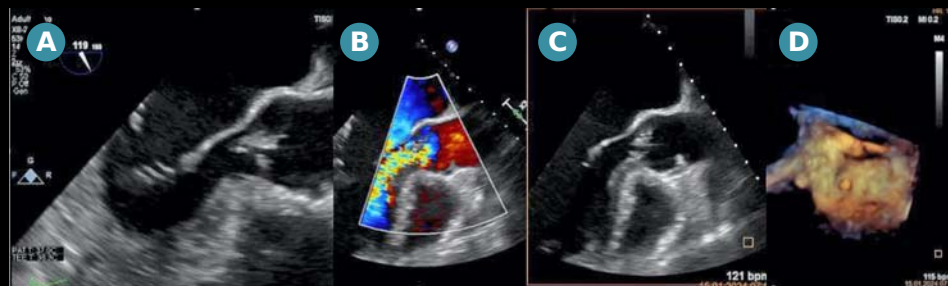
The transesophageal examination shows morphological changes of the aortic valve in the longitudinal axis and a structure that is highly suggestive of attachment to the left aortic cusp (A), which causes severe aortic regurgitation (B). In addition, at the level of the anterior aortic wall, 3 cm from the aortic annulus, there is a small structure suggestive of endarteritis (C) also visible in 3 D (D)
